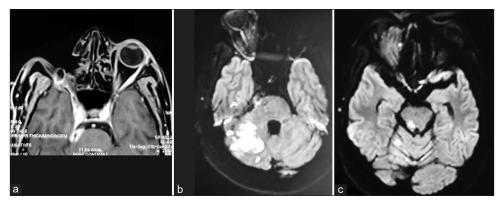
(a) An operated case of right rhino-orbito-cerebral mucormycosis (ROCM) with progressive disease in the right cavernous sinus with extension into right pre-pontine, pre-medullary, and cerebellopontine angle cisterns as seen on magnetic resonance images of the brain taken 3 months postsurgery. (b and c) Diffusion-weighted images (DWI) of the same patient showed increased signal intensity in the right hemicerebellum, right brachium pontis, and the right lateral aspect of pons suggestive of an infarct.
